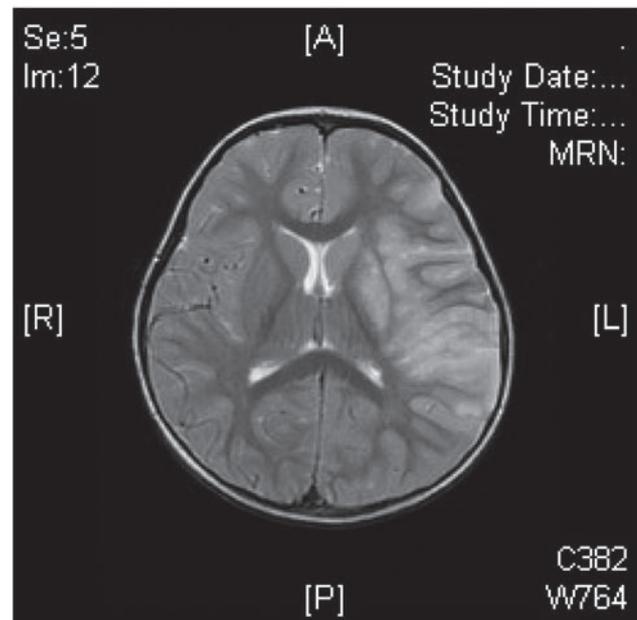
MRI brain. T1 slightly hypointense and T2 hyperintense DW hyperintense changes without significant contrast enhancement was seen involving the left frontal lobe and parietal lobe.
